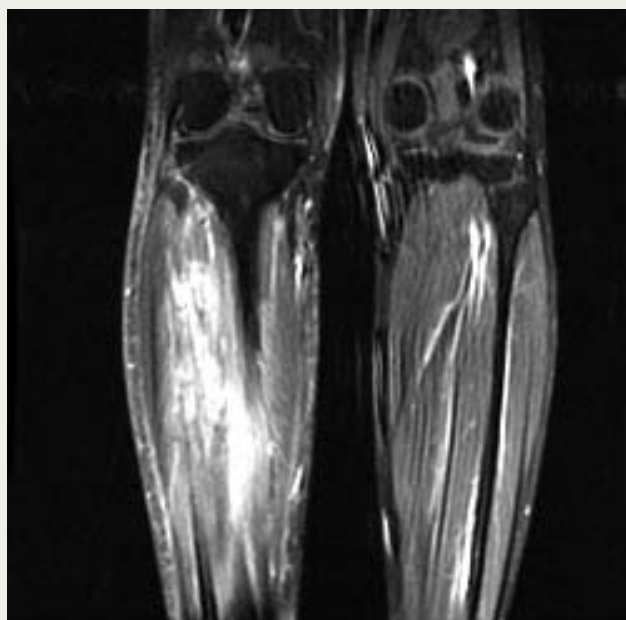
MRI views of the patient’s leg show increased signal within the bulk of the anterior tibialis, hallucis longus, and peroneus longus muscles and, more distally, the peroneus brevis muscle.
